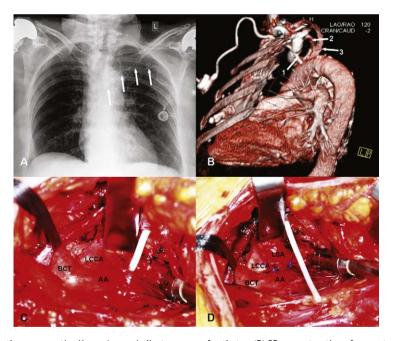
(A) Port-a-cath as shown in the preoperative X-ray. Arrows indicate course of catheter. (B) 3D-reconstruction of computed tomography scan (left-posterior view) displays the port-a-cath (1) penetrating the aortic arch between the origin of the left carotid (2) and left subclavian artery (3). (C and D) Intra-operative view of the Port-a-cath before (C) and after removal (D) from the aortic arch. After sternotomy and extrapericardial exposure of the aortic arch, two purse string sutures were placed on the aortic arch around the device which allowed port removal without bleeding. AA: aortic arch; BCT: brachio-cephalic trunk; LCCA: left common carotid artery; LSA: left subclavian artery.
